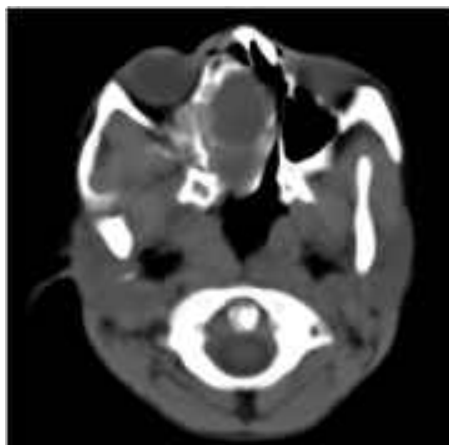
(Axial CT image). Mass completely filling the right nasal cavity and maxillary sinus.
